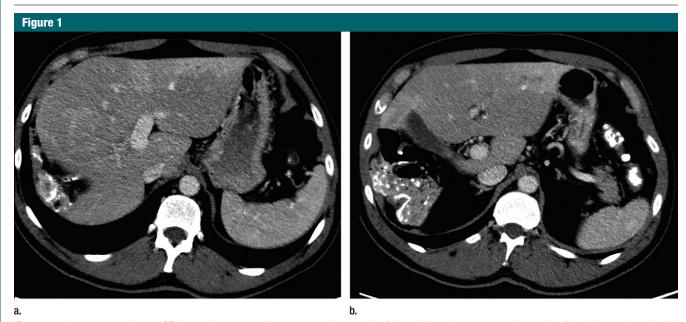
Axial contrast-enhanced CT images in a 49-year-old man with marked atrophy of the right liver due to complete obstruction of the right portal vein. (a, b) Portal venous phase images obtained at different levels show right atrophy with displacement of the gallbladder.
